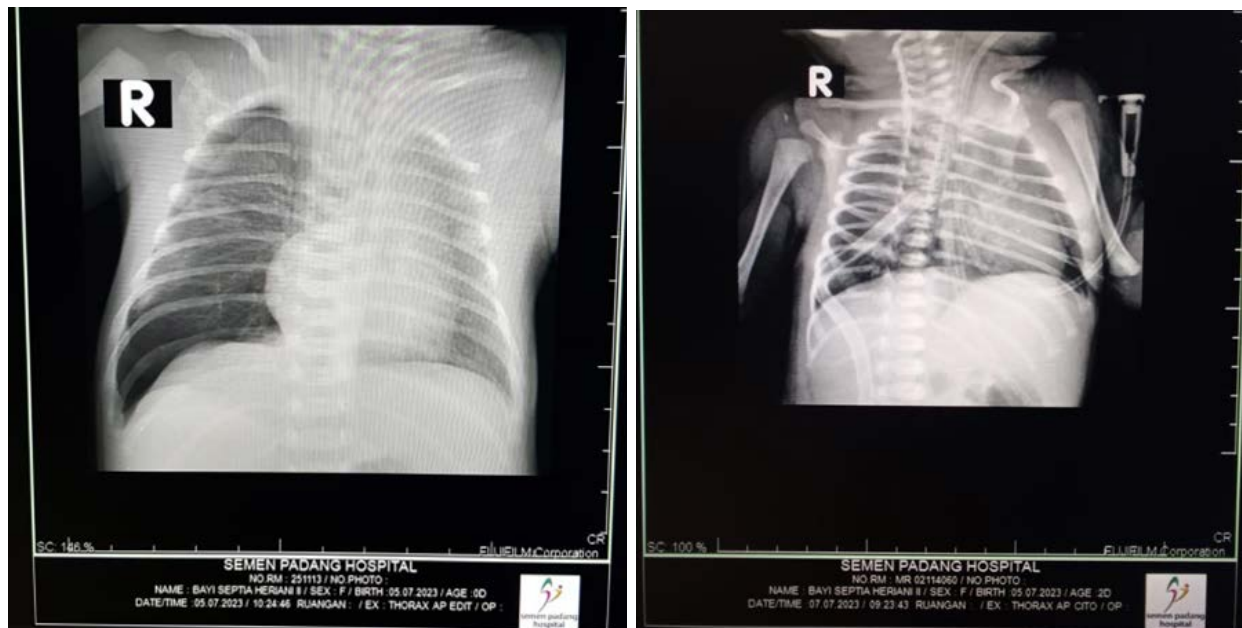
Chest X-ray 1st day of life showed right pneumothorax with lung collapse
